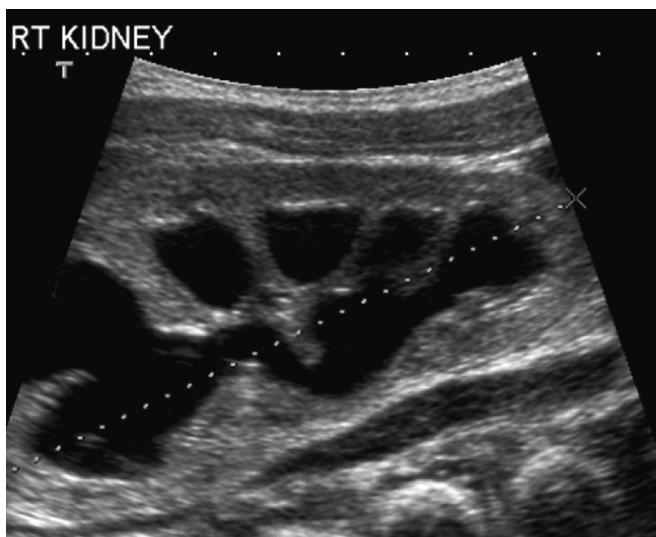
Neonatal hydronephrosis. Sonogram of the right kidney in a 1-day-old neonate with a history of prenatal hydronephrosis demonstrates severe dilation of the collecting system.
